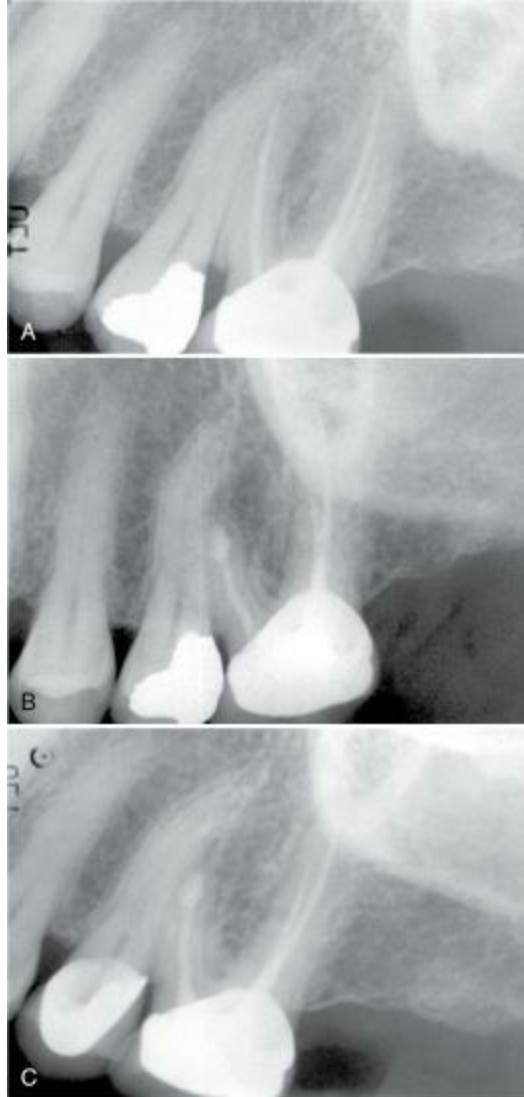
A, Previously treated maxillary first molar with persistent periradicular disease and obvious transportation of the main mesiobuccal (MB-1) canal. Nonsurgical retreatment is unlikely to correct this iatrogenic condition, and surgery is the preferred choice. B, Immediate postsurgery radiograph. The root-end preparation and fill was extended from the MB-1 canal in a palatal direction to include the isthmus area and the second (MB-2) canal. C, One-year follow-up examination: the tooth is asymptomatic, and periradicular healing is apparent radiographically. Although surgery was the first-choice treatment in this case and the outcome was favorable, a good argument could be made for nonsurgical retreatment before surgery to ensure disinfection of the canal and to attempt to locate a MB-2 canal.
